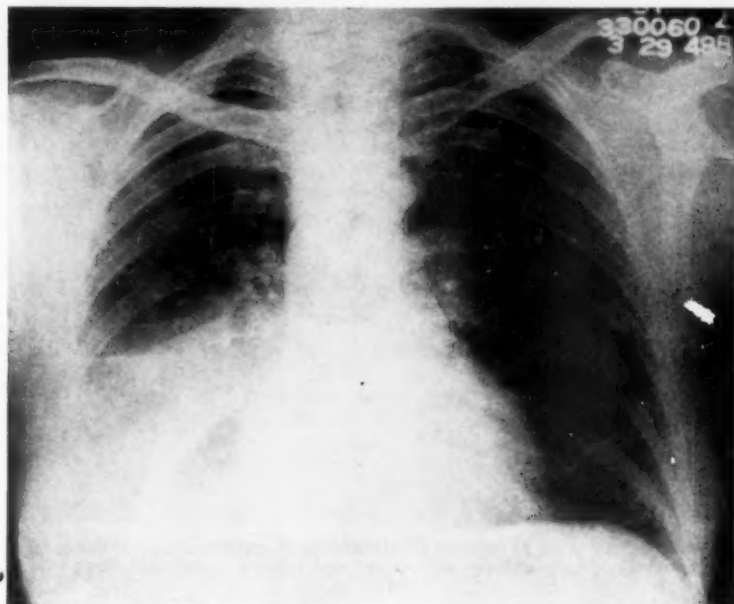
Chest x-ray taken 16 days later, immediately after thoracentesis, to show that no air was present in the pleural cavity.
